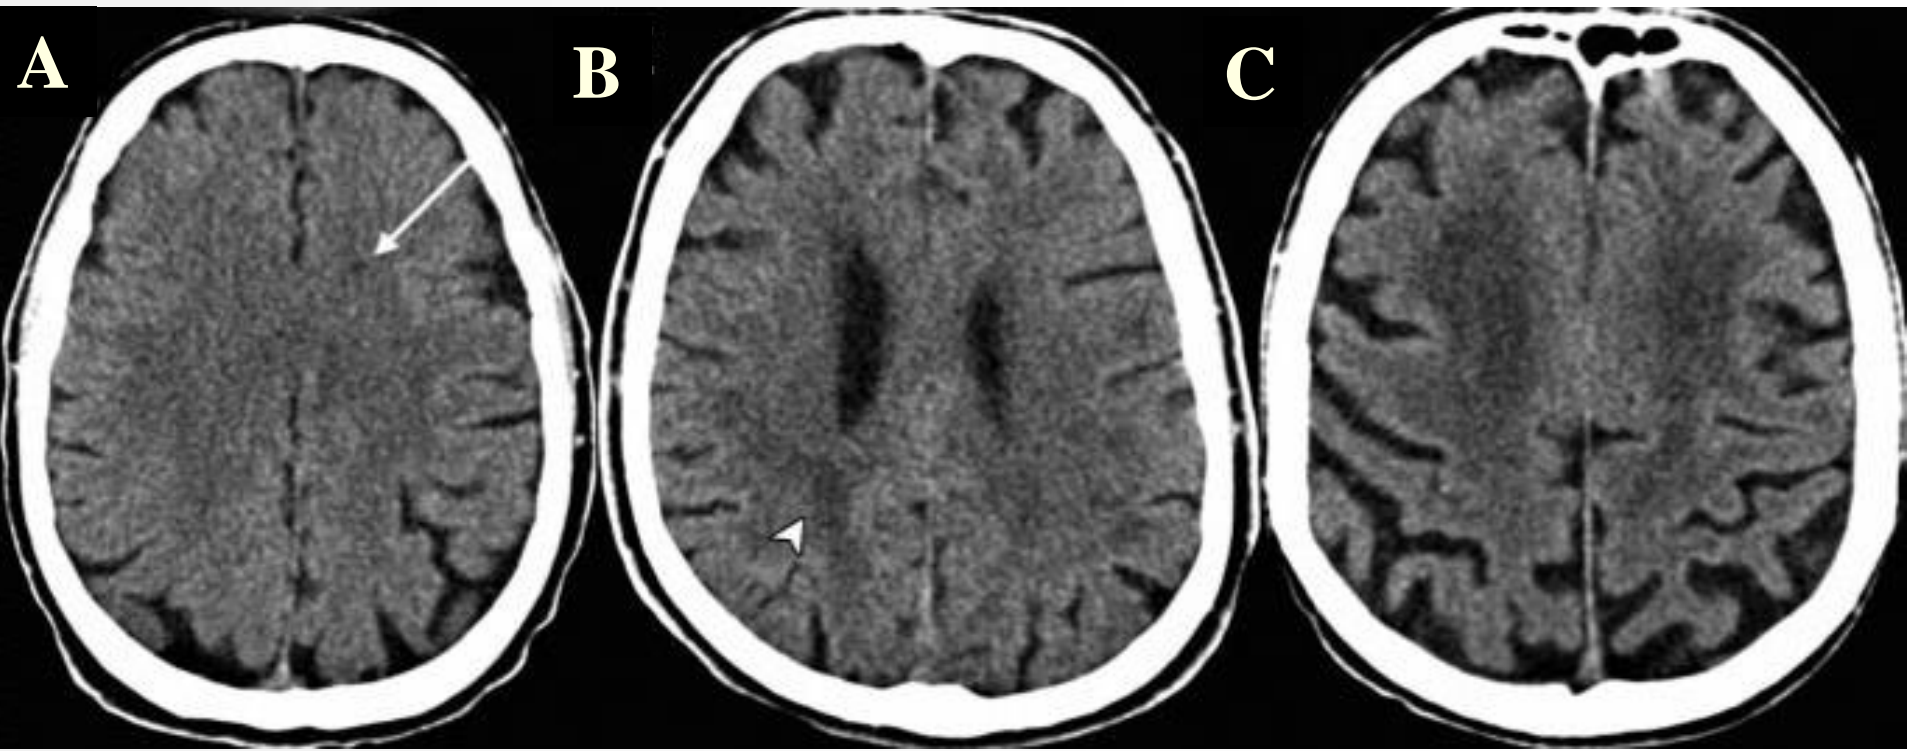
CT images of Fazekas 1-3. A – Fazekas 1, B – Fazekas 2, C – Fazekas 3 [7].
